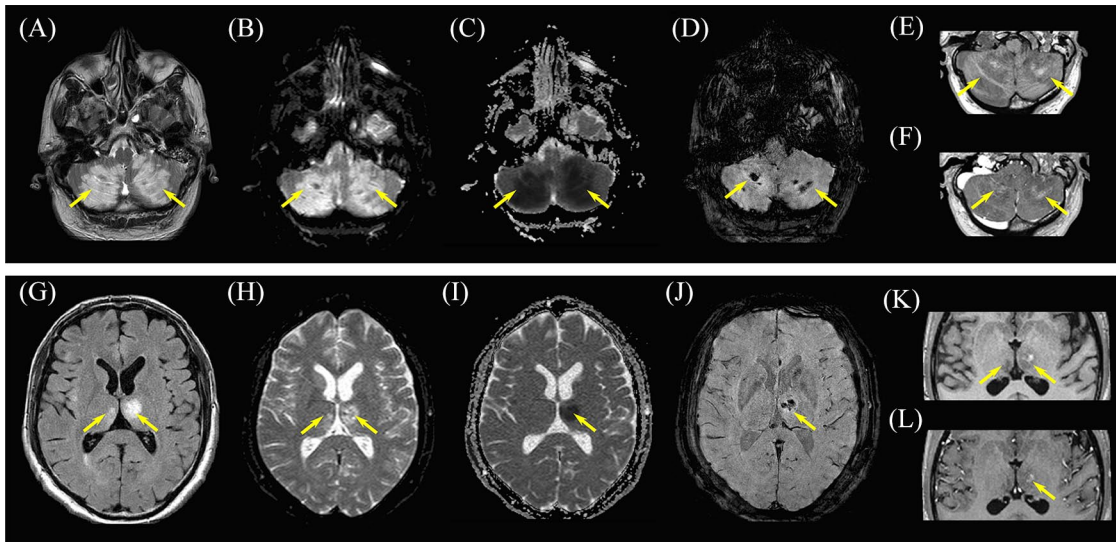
Brain MRI. Widespread bilateral cerebellar and thalamic lesions (arrows) showing a hyperintense signal on axial fluid-attenuated inversion recovery images (A, G), restricted diffusion (cytotoxic edema) on diffusion-weighted images (B, H), and apparent diffusion coefficient maps (C, I), hemorrhages on susceptibility-weighted images (D, J), hypo-hyperintense signal on T1-weighted pre-contrast images (E, K), and contrast enhancement on T1-weighted post-contrast images (F, L). MRI, magnetic resonance imaging.
